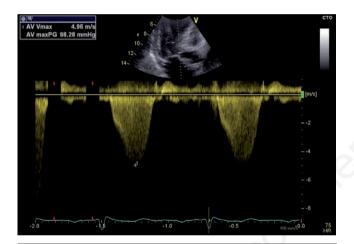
Continuous-wave doppler demonstrating a LVOT late peak gradient of 98 mmHg at time of TTC onset.
